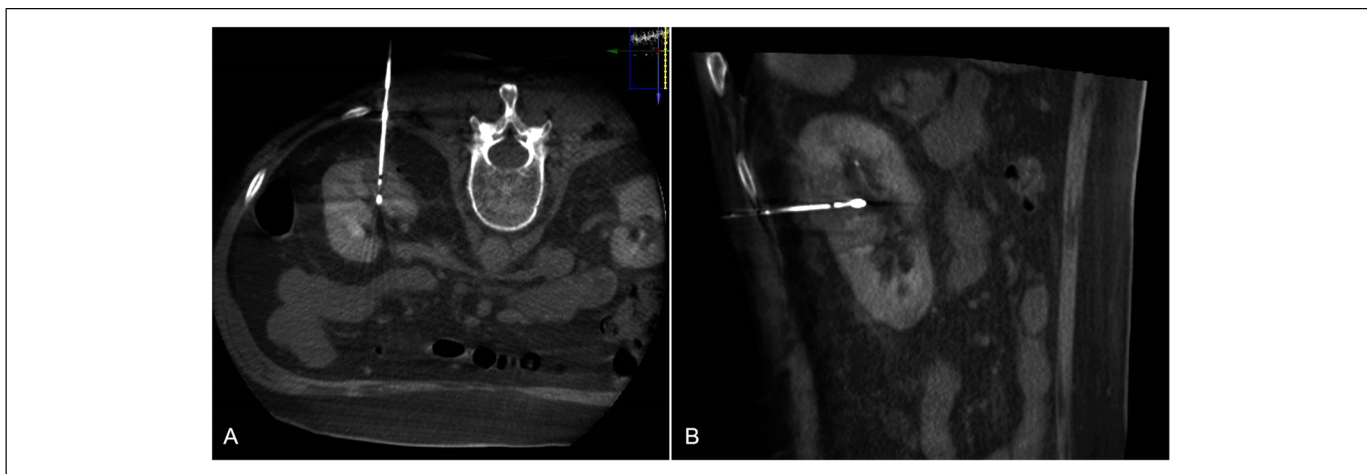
Final contrast-enhanced CBCT identifying the tumor was used to visualize the antenna, in order to check the correct position within the tumor itself: axial (A) and sagittal (B) views.
